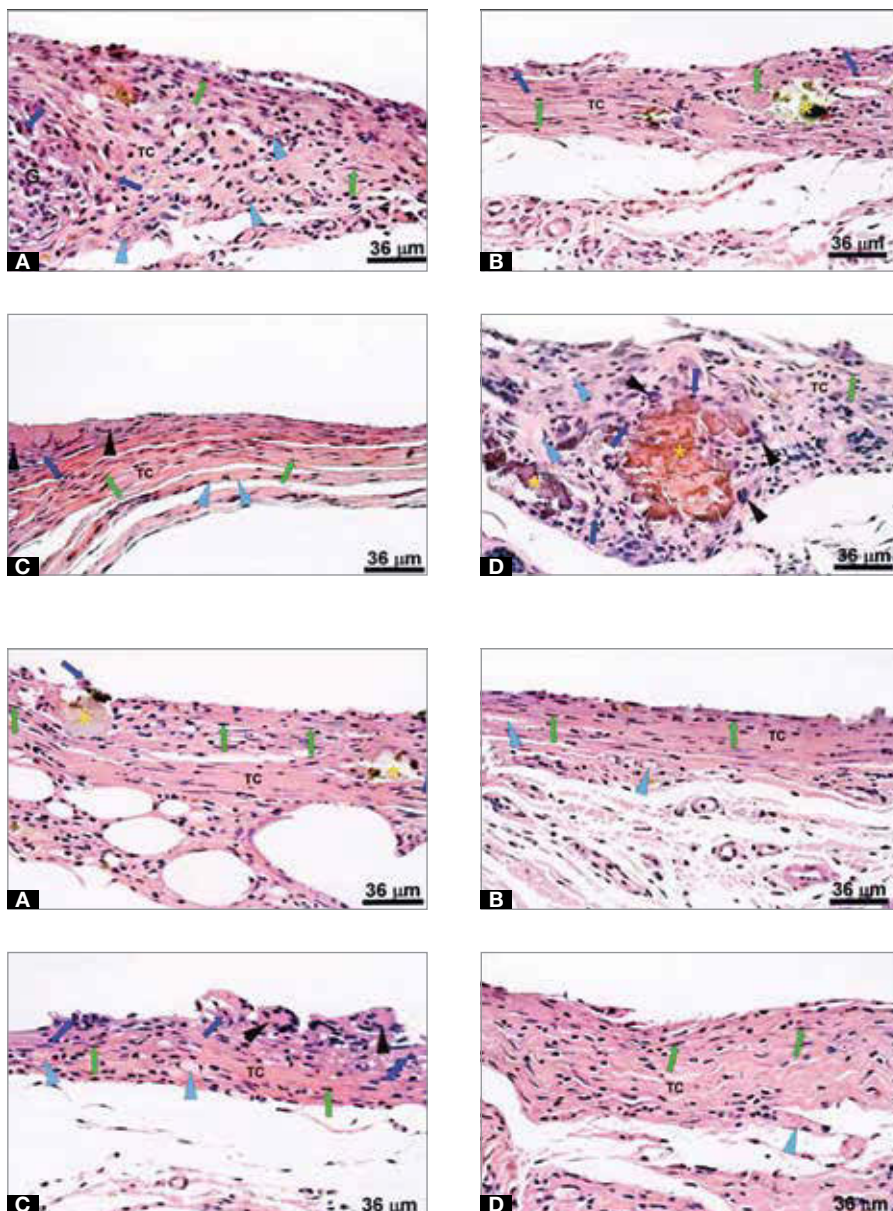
15 days: A) Clincker without calcium sulfate; B) Clicker with 2% calcium sulfate; C) Clincker with 5% calcium sulfate; D) CPM sealer. (blue arrow: macrophage; blue arrow head: blood vessels; black arrow head: giant cells; CT: connective tissue; green arrow: fibroblasts; asterisk: extruded material). HE 40x
